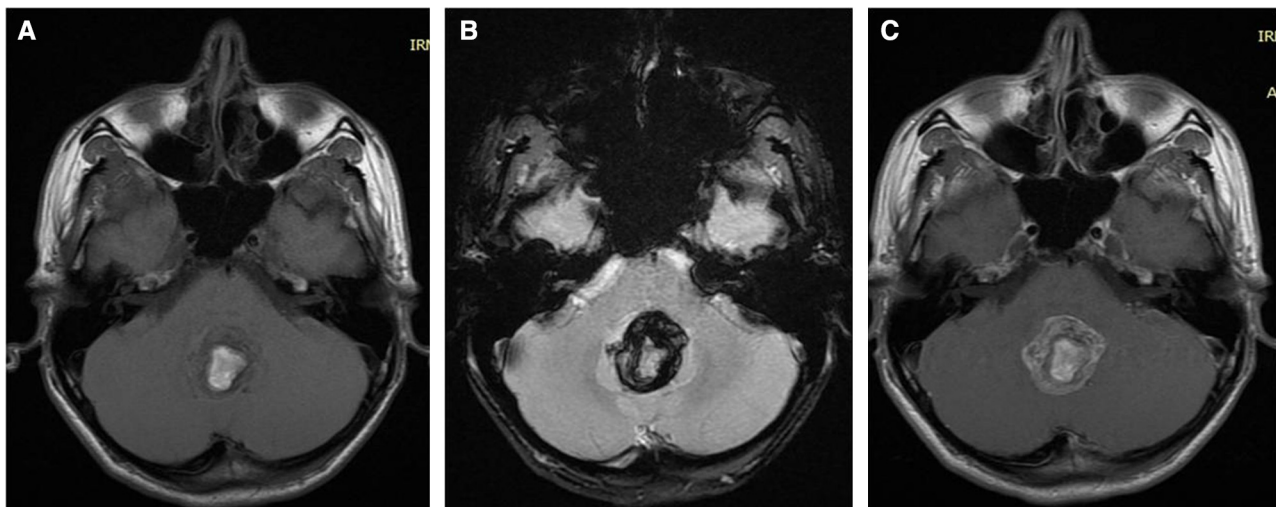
Brain MRI including axial T1 (A), T2\* (B) and T1 post-contrast (C) sequences showing a cerebellar mass arising from the inferior vermis and protruding within the fourth ventricle showing mixed signal intensity consisting of a central high-signal mainly on T1WI and peripheral stratified low-signal intensities on T2\* with hypointense delineating the brainstem and the ponto-cerebellar angles. Different stages of hemorrhage with superficial siderosis. Demonstration of thick and heterogeneous peripheral enhancement.
